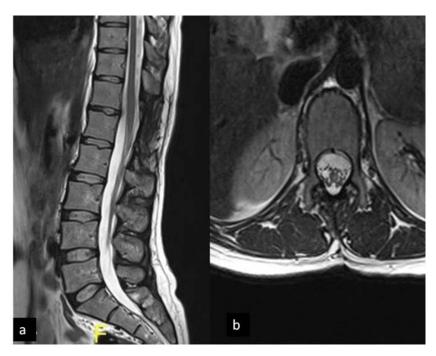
(a) Sagittal and (b) axial sections of postoperative first year follow up MRI, no lesion was detected
